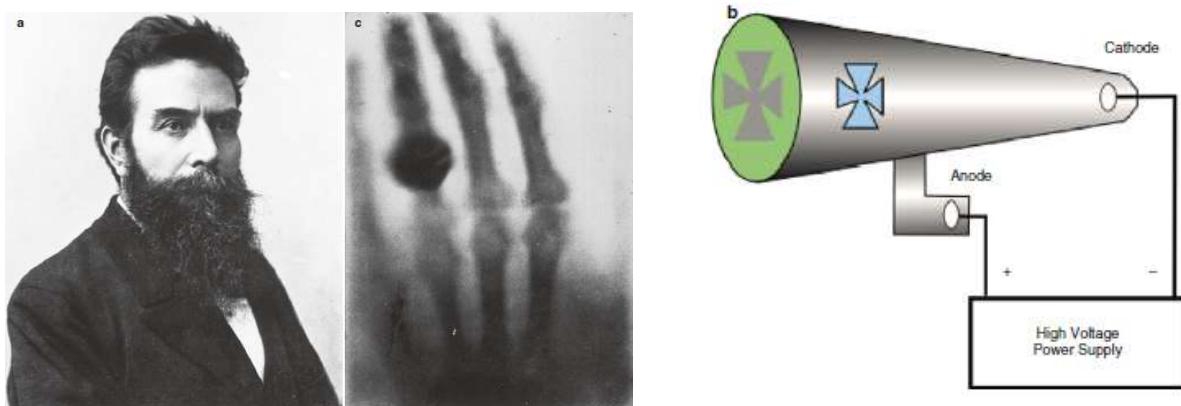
a) Wilhelm Roentgen, b) the first X-ray photograph of a human body (the hand belongs to Wilhelm Roentgen's wife) b) the concept of X-ray tube
